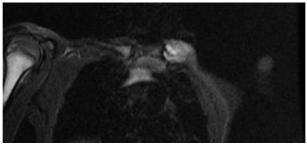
MRI showing diffuse STIR hyperintense marrow edema of the metaphysis of the right humerus and medial ends of both clavicles
